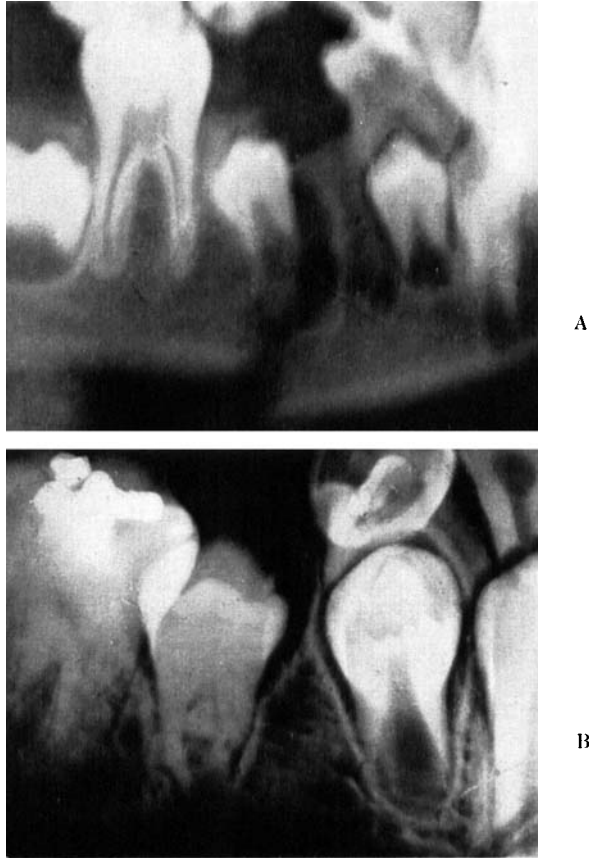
♀ aged 9 years. Fracture of the mandible (regio 5—) when the patient was 8 years of age. A shows the state immediately after the fracture. B is a radiograph taken 14 months after the fracture. Note the deficient root formation and the almost obliterated pulp chamber of 5—.
